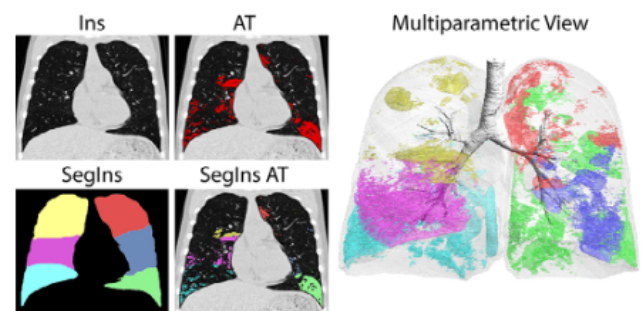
Spatial alignment of QCT metrics to the inspiratory frame (i.e. Method 4). Presented is a representative coronal slice in the inspiratory frame for the CT scan (Ins), air trapping map overlaid on Ins (AT), lobe segmentation map (SegIns) and AT coded for each lobe overlaid on Ins (SegIns on AT) acquired from a 8-year-old female diagnosed with mild CF at the time of accrual. A multiparametric view of the 3D rendered airway tree and AT coded for each lobe allow for visualization and quantification of local disease. Individual lobes presented in the multiparametric view are color-coded as yellow for right upper lobe (RUL), magenta for right middle lobe (RML), cyan for right lower lobe (RLL), red for left upper lobe (LUL), blue for lingula (LLi) and green for left lower lobe (LLL). (Color version of figure is available online.).
